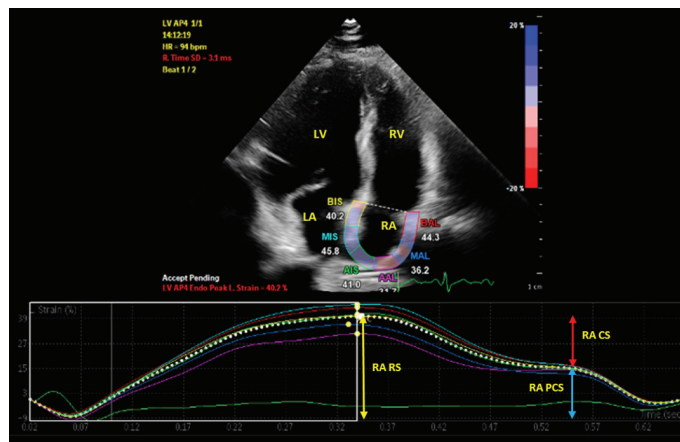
Right atrial strain imaging using 2D speckle-tracking echocardiography from the apical four-chamber view in a study patient. The yellow arrow indicates reservoir strain (RS), the blue arrow indicates peak contraction strain (PCS), and the red arrow indicates conduit strain (CS).
